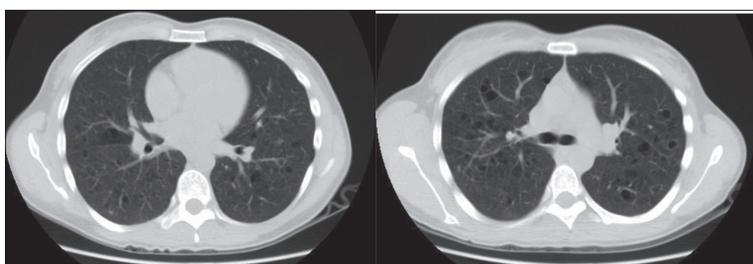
Chest high-resolution computed tomography of the patient with pulmonary Langerhans cell histiocytosis after three years
